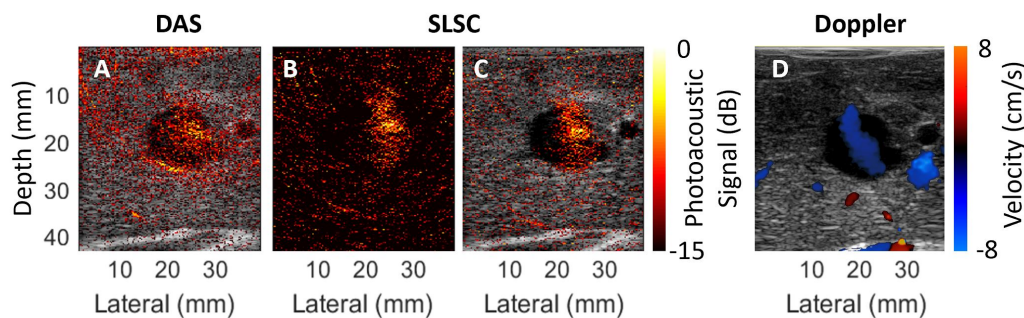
(A) DAS beamformed photoacoustic image of signals in *in vivo* liver overlaid on co-registered US image. (B) Corresponding SLSC beamformed photoacoustic image created with the same channel data. (C) SLSC beamformed photoacoustic image overlaid on US image. The photoacoustic images were acquired with 40.8 mJ energy. (D) Color Doppler confirmation of blood flow in the hepatic vein.
